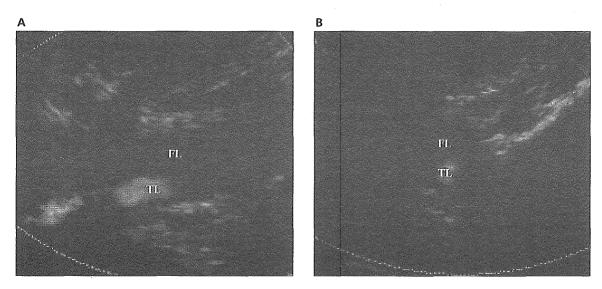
Color Doppler studies of the right distal ICA by TOCU on day 2. A, Longitudinal view shows a septum (arrow) separating the true lumen from a false lumen and narrowing of the true lumen (arrowhead). B, Short axial view at the narrowing of the true lumen also shows the true and false lumens. FL indicates false lumen; and TL, true lumen.
